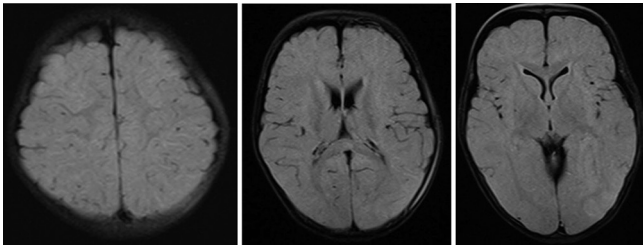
FLAIR images show mild hyperintensities in the subcortical white matter.
